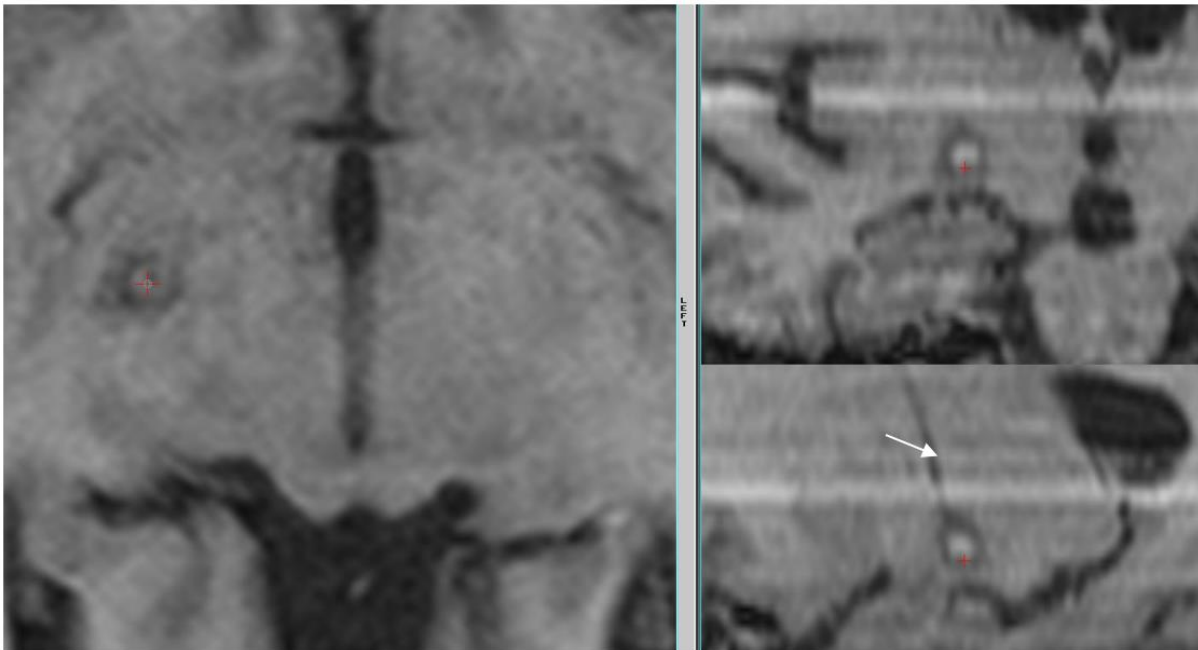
Postoperative MRI T1: Hyperintense right Gpi lesioning (red cross). a. axial -4 level, b. coronal and c. sagittal plane. Hypointense entering tract (white arrow)
